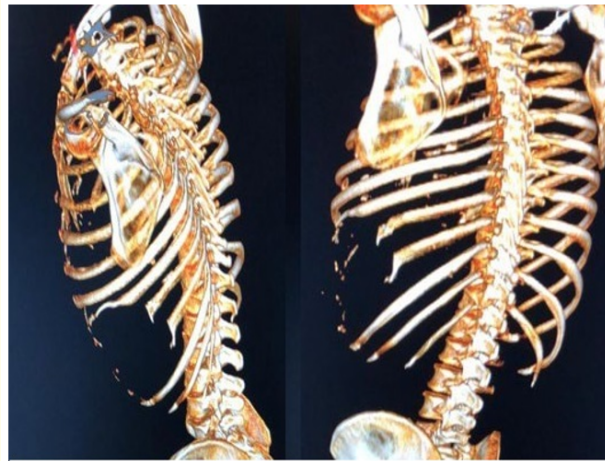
Reconstruction of the chest wall from the CT scan showing the remnants of the 8th, and 9th ribs.
